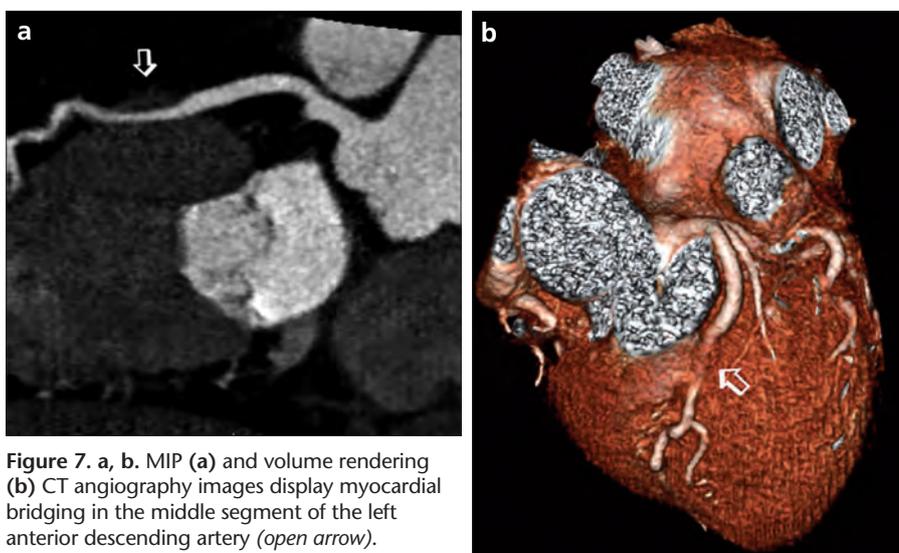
a, b. MIP (a) and volume rendering (b) CT angiography images display myocardial bridging in the middle segment of the left anterior descending artery (*open arrow*).
